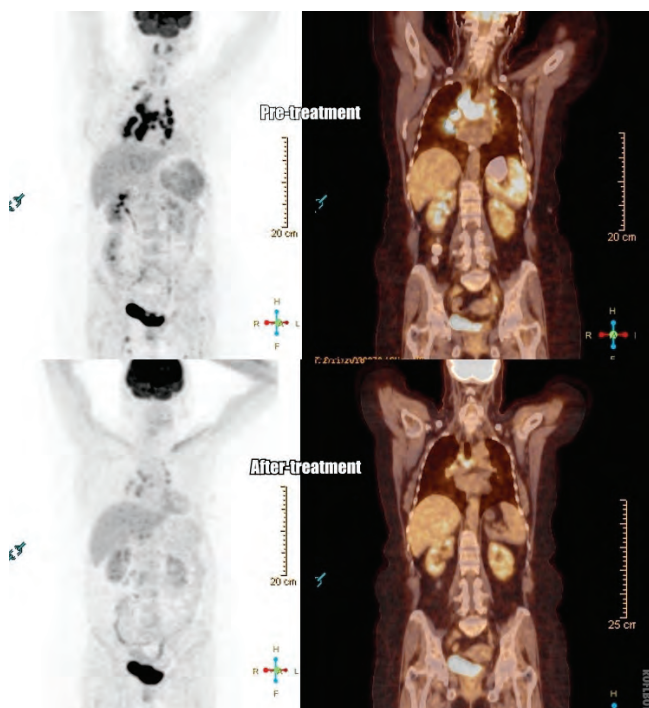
Supra-infraclavicular, mediastinal, intraabdominal hypermetabolic LAPs were observed significant metabolic and morphologic regression on PET-CT images three months after initializing of treatment. In the spleen was observed complete regression findings as metabolic and morphological.
